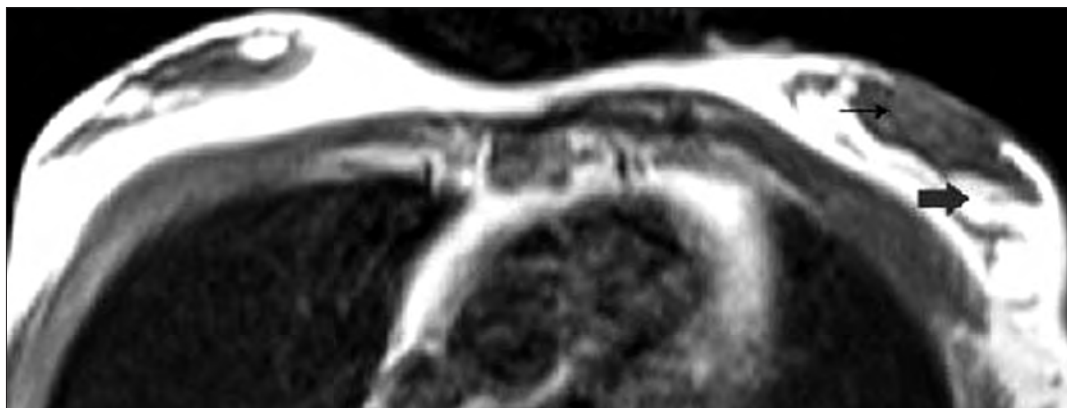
An axial T1-weighted MR image showing breast parenchyma with a low signal intensity due to the presence of glandular tissue (*narrow arrow*), outlined by a high signal intensity of the surrounding fat (*wide arrow*).
